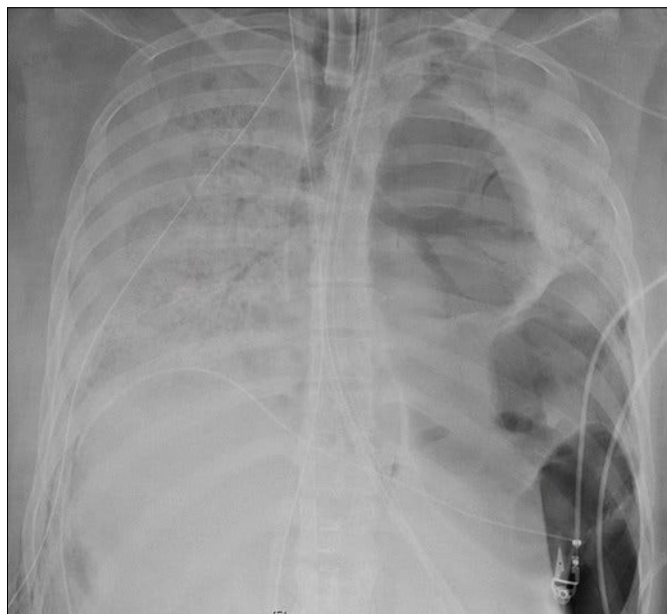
An X-ray of the patient's lungs before surgery. Northwestern Medicine
